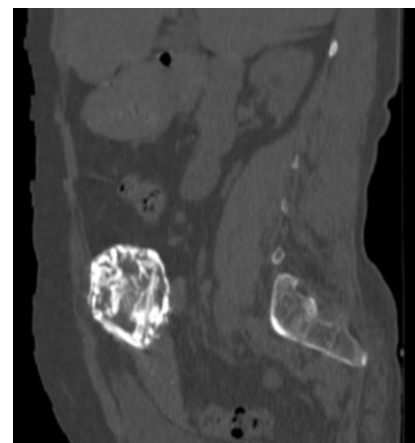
Plain CT sagittal section reveals: a well-defined calcified ovoid lesion, suggestive of a mummified fetus with detailed anatomy.
